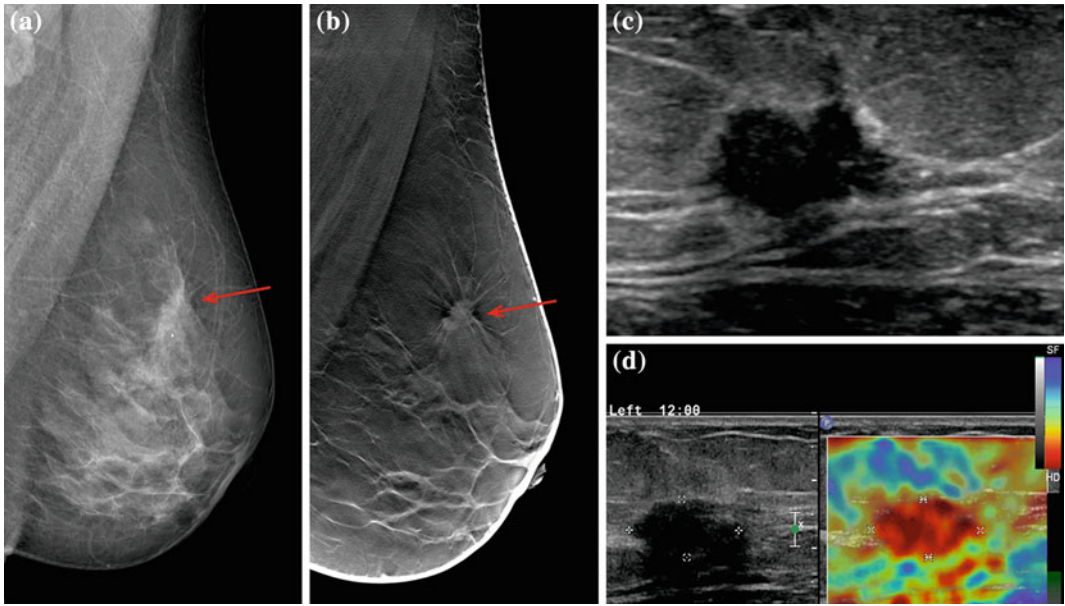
16 mm invasive ductal cancer in a 42-year-old woman. Mammography (a) shows an architectural distortion. Tomosynthesis -1 mm slice (b) reveals a spiculated mass. Ultrasound (c) shows a solid hypochoic
